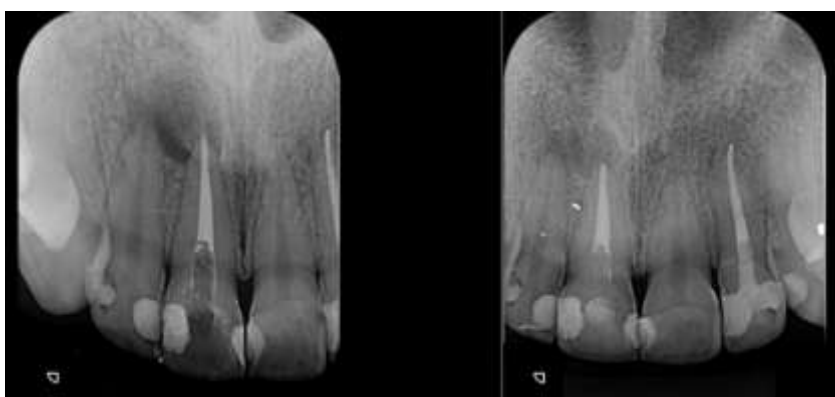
Periapical lesion in repairing phase associated with the root apex of element 11 after 1 year and 7 months.
